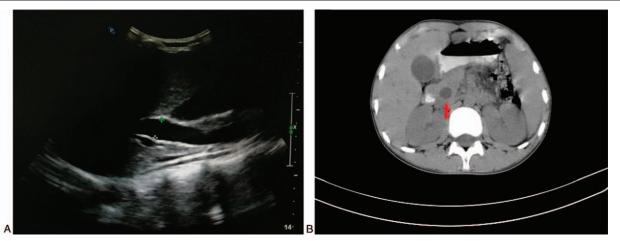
Abdominal imaging performed 2 days after admission of the 14-year-old male patient. (A) Ultrasonography revealed dilatation of the extrahepatic bile duct (inner diameter: approximately 14 mm at the widest segment). Dilatation of the extrahepatic bile duct and splenomegaly were also detected (not shown). (B) Computed tomography demonstrated similar findings to those of ultrasonography.
